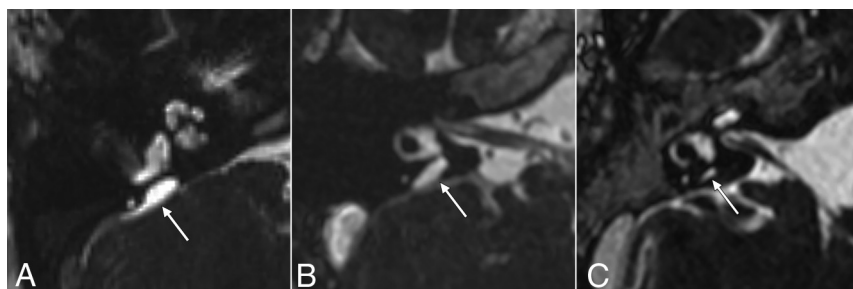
CISS MR images demonstrating additional examples of type 3 (easily visible) ELDs (arrows) in 3 different patients. A, A 7-month-old girl with severe SNHL in the right ear. B, A 6-year-old boy with severe SNHL in the right ear. C, A 4-year-old girl with mild SNHL in the left ear. All patients in these images demonstrated EVA on CT.
